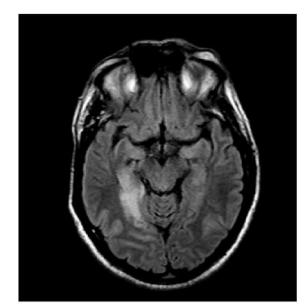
Magnetic Resonance Images: Dreaming patient (#5)
